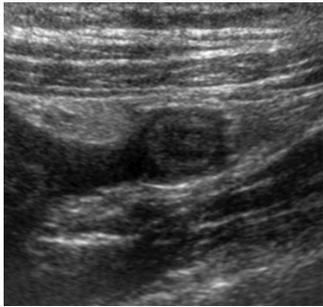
Transverse sonogram reveals 'target appearance' of appendicitis
